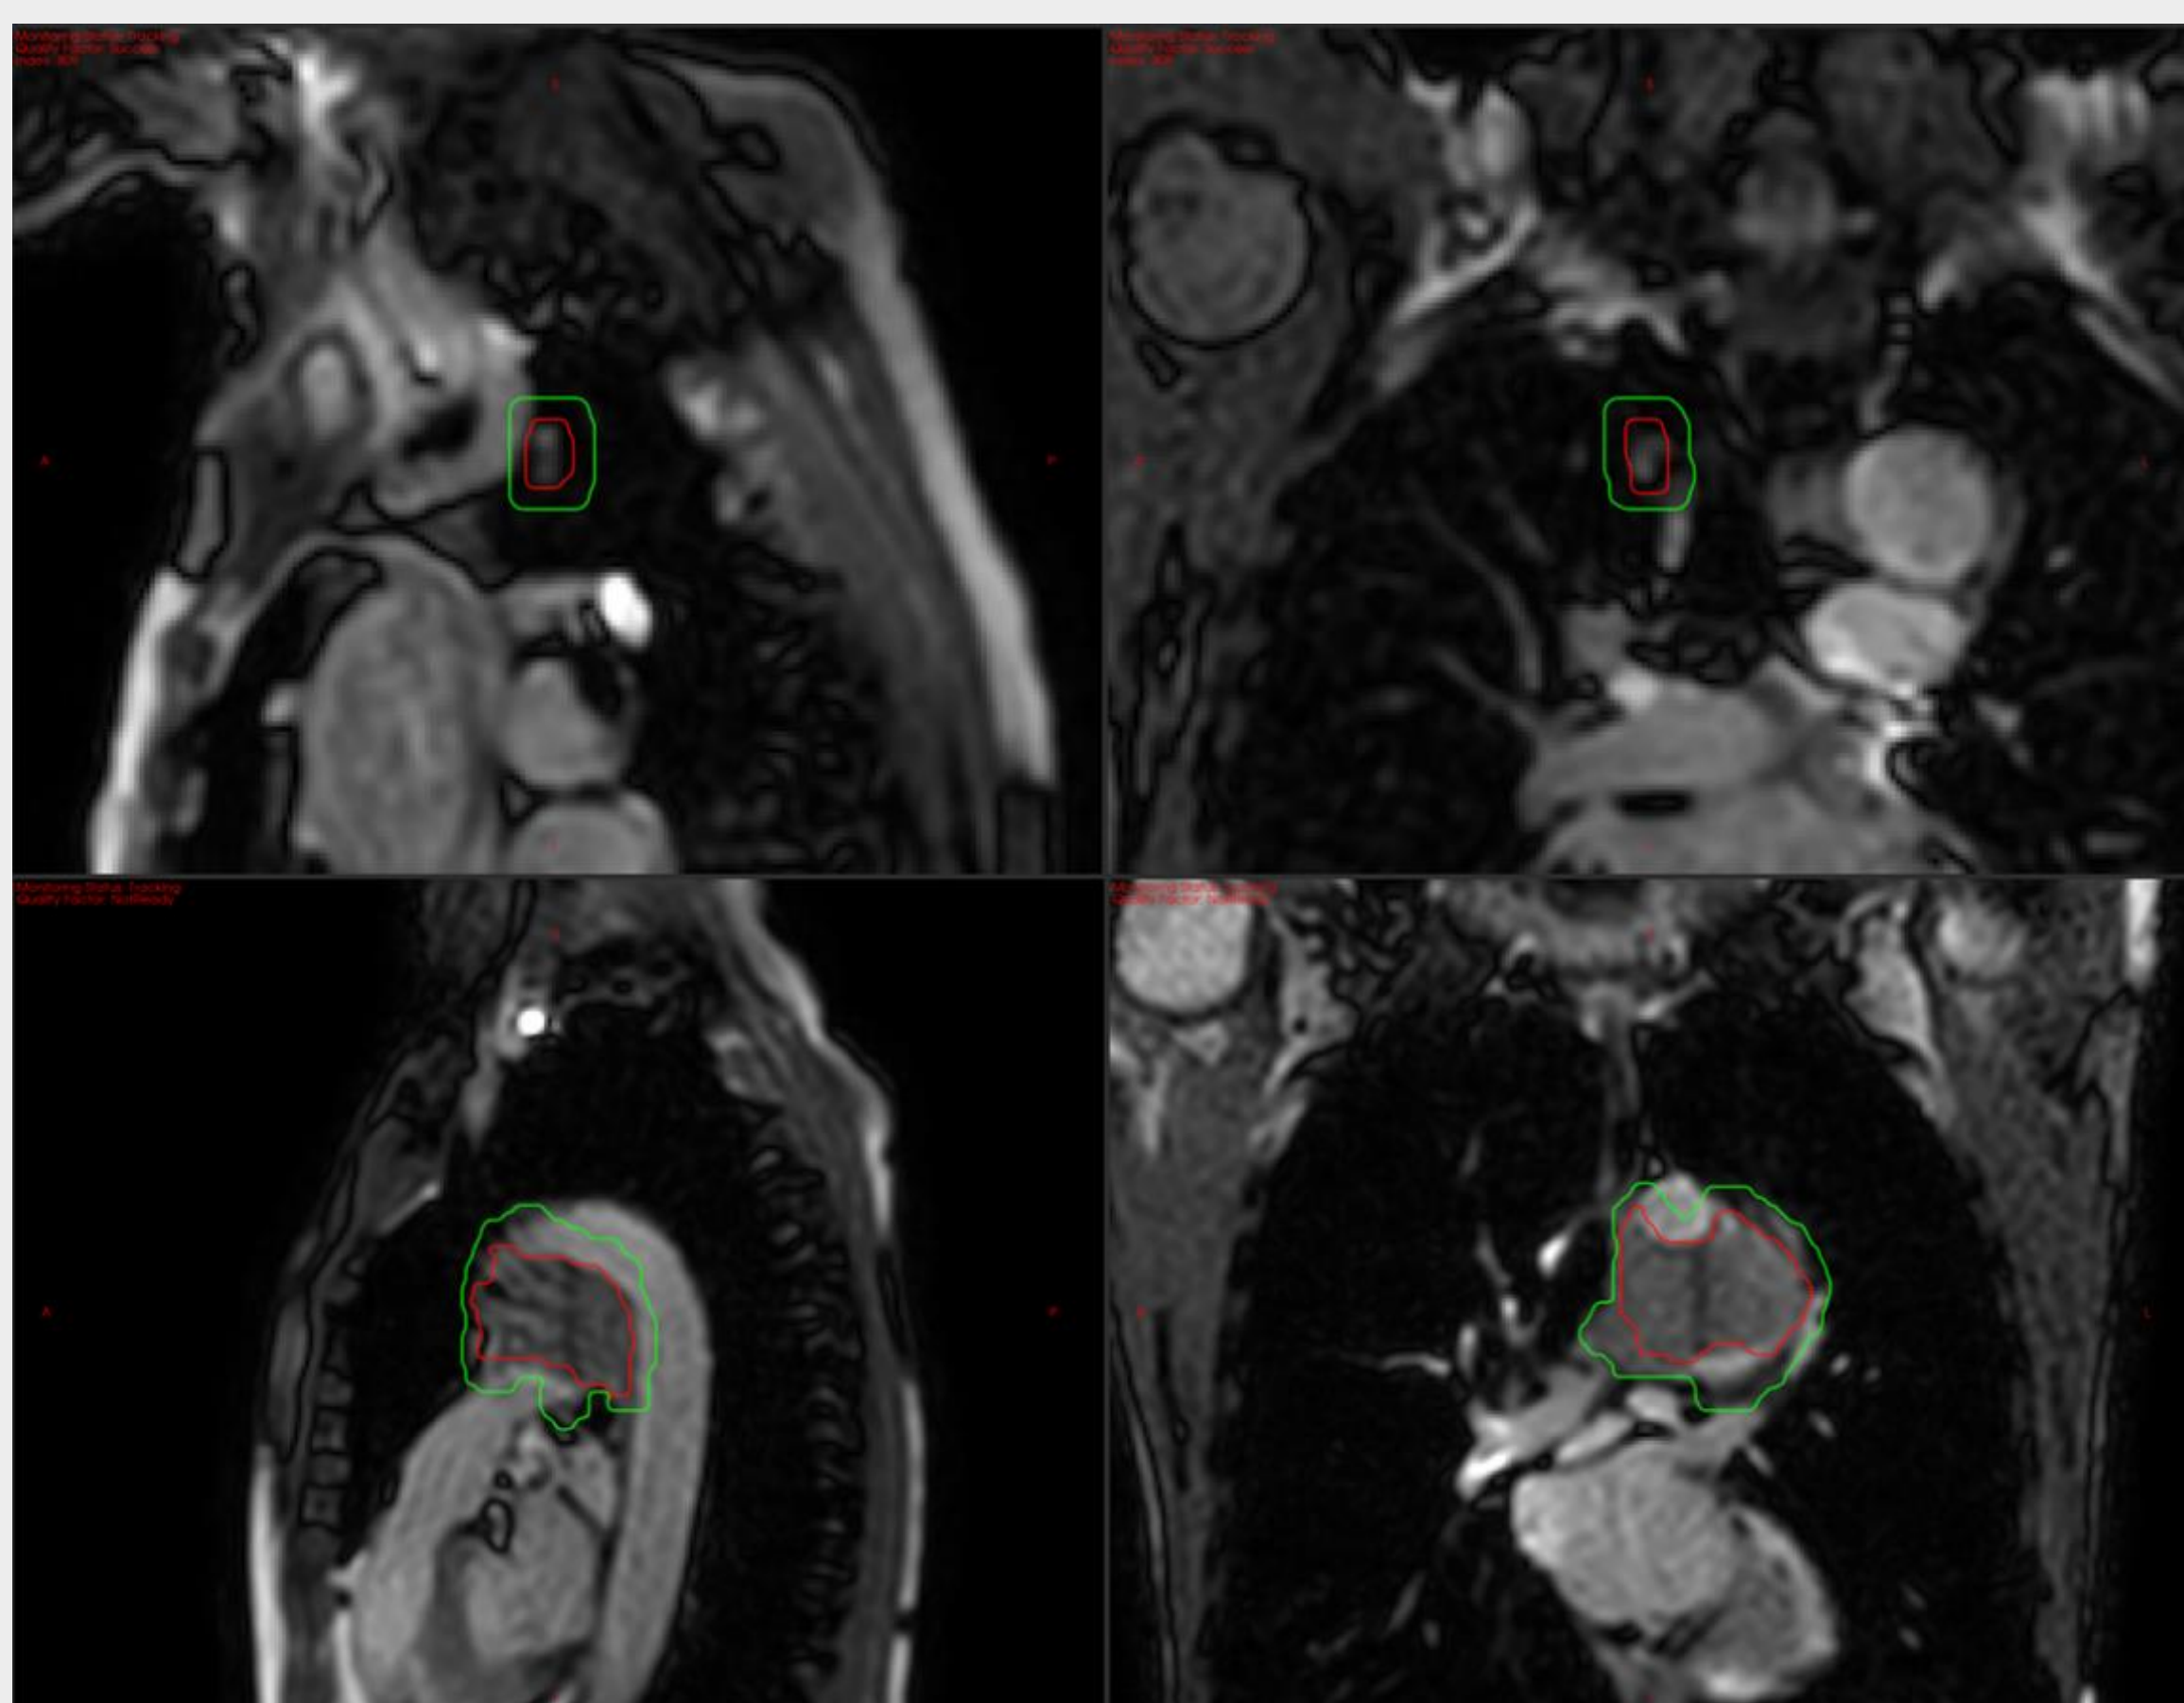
Representative cine MR images from two example patients emulated for tracking surrogate selection, showing the surrogate regions of interest (green) used to maximize tumor visibility (red) while excluding adjacent structures with independent motion.
